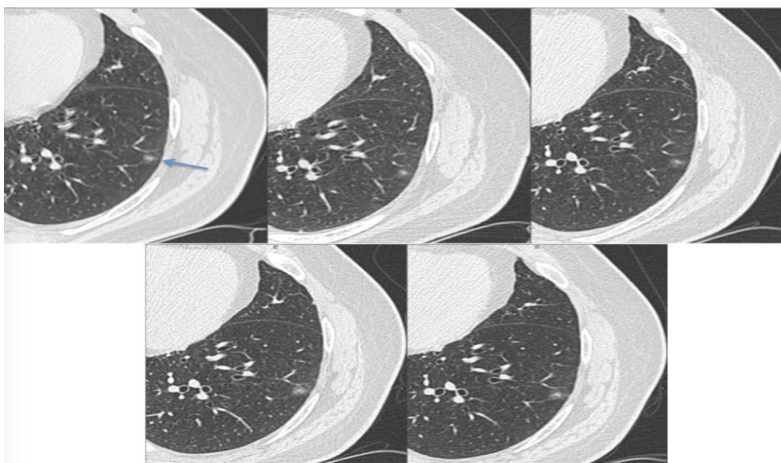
Patient 1: Five serial CT images spanning 826 days (as detailed in the text) for a biopsy proven benign GGO (arrow).
